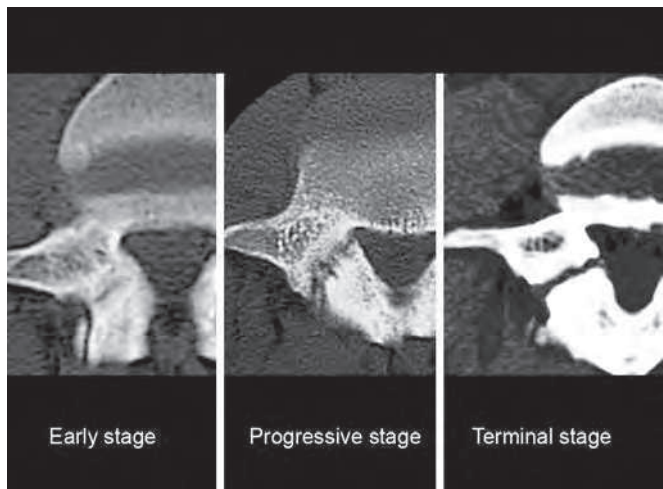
Representative computed tomography (CT) scans of pars defects in each stage. On the basis of CT findings, the defect is classified into three stages: early, progressive, and terminal.⁷³
